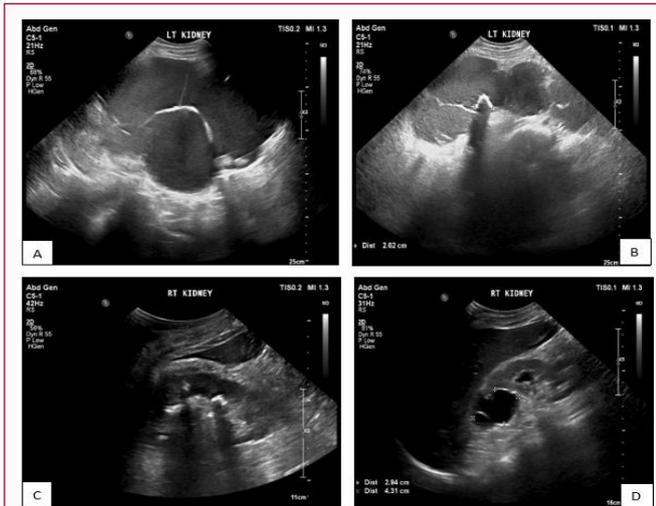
Abdominal ultra sonography reveals multiple left renal calculi with diffuse loss of parenchyma [A&B], while the right kidney contains multiple obstructing renal calculi and large upper pole cyst measuring 3 cm x 4 cm [C&D].
